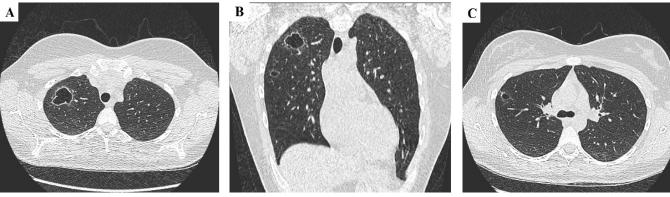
(A) – An axial chest CT scan presenting a pneumatocele in the right lung with a slightly thickened wall (B) – A cross-sectional chest CT scan demonstrating two pneumatocele in the right lung (C) – An axial chest CT scan presenting the second small pneumatocele in the right lung
